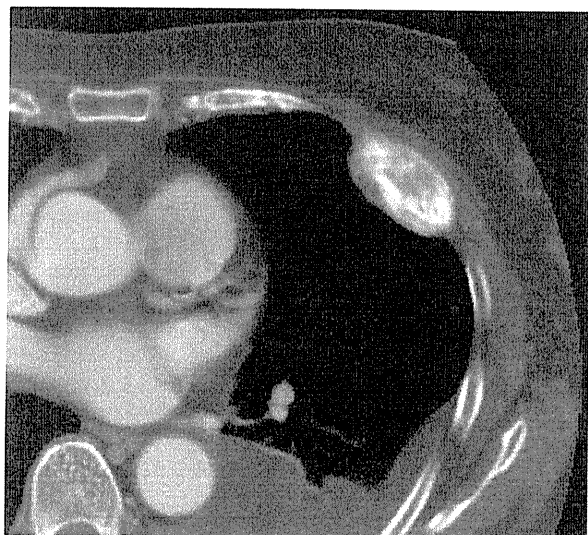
Computed tomographic image showing cortical disruption and "honeycomb" appearance of trabeculae, along with a left-sided, large pleural effusion.
